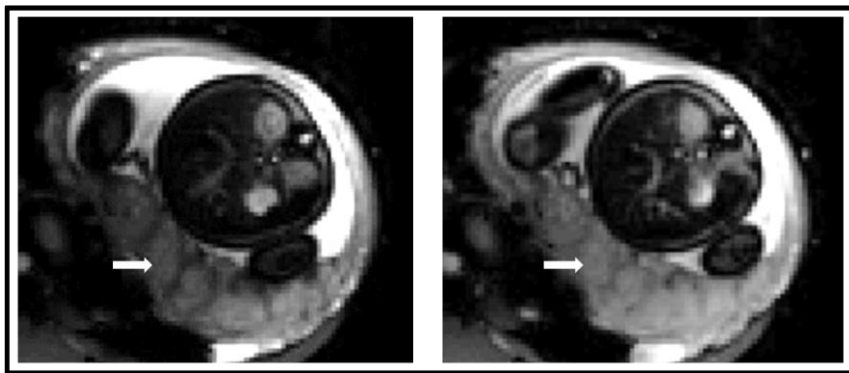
Placenta BOLD MR images in a normal pregnancy at 36 weeks' gestation. Cross-section through the central part of the placenta during normoxia (left) and during maternal oxygen-challenge (right). Placenta marked with white arrows.
